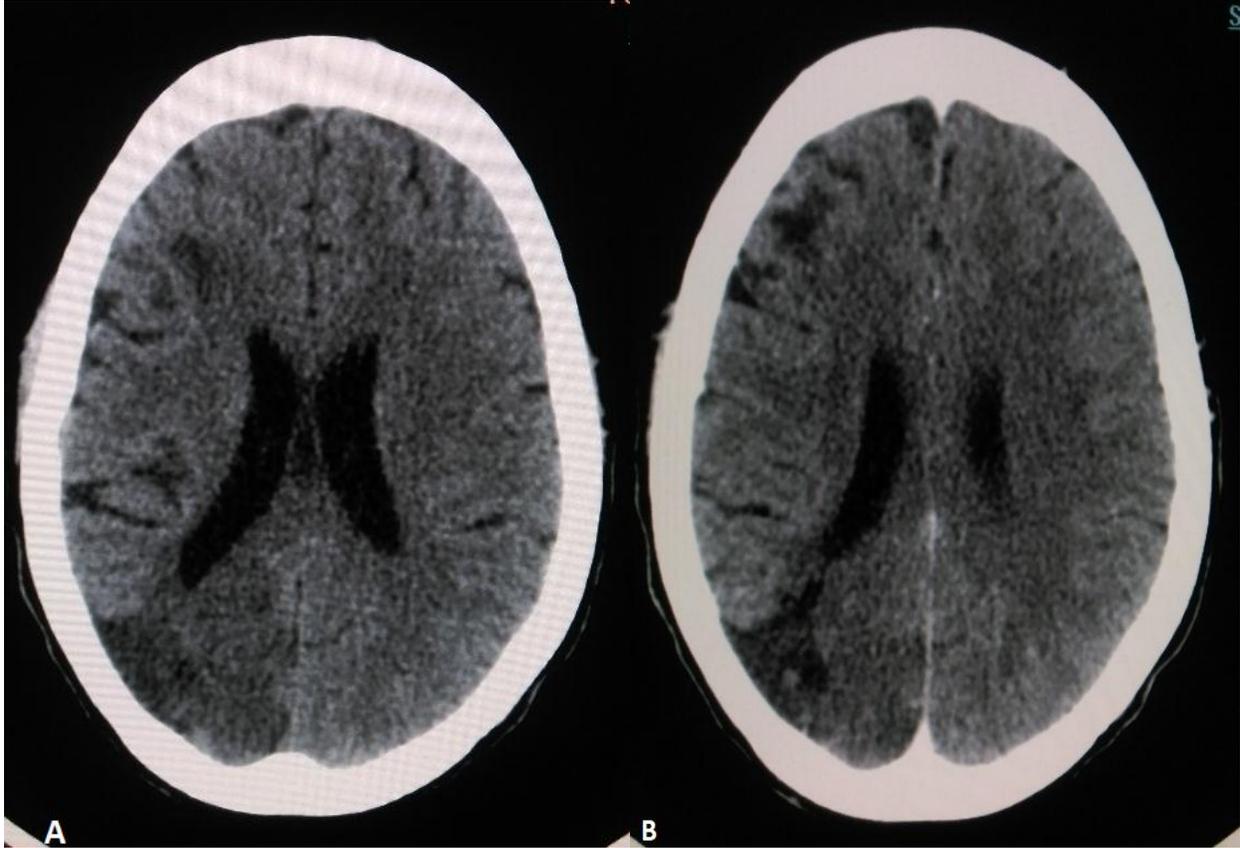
Axial CT brain (A) precontrast and (B) post contrast images showing a nonenhancing wedge shaped hypodensity in the right occipital lobe in keeping with infarction
